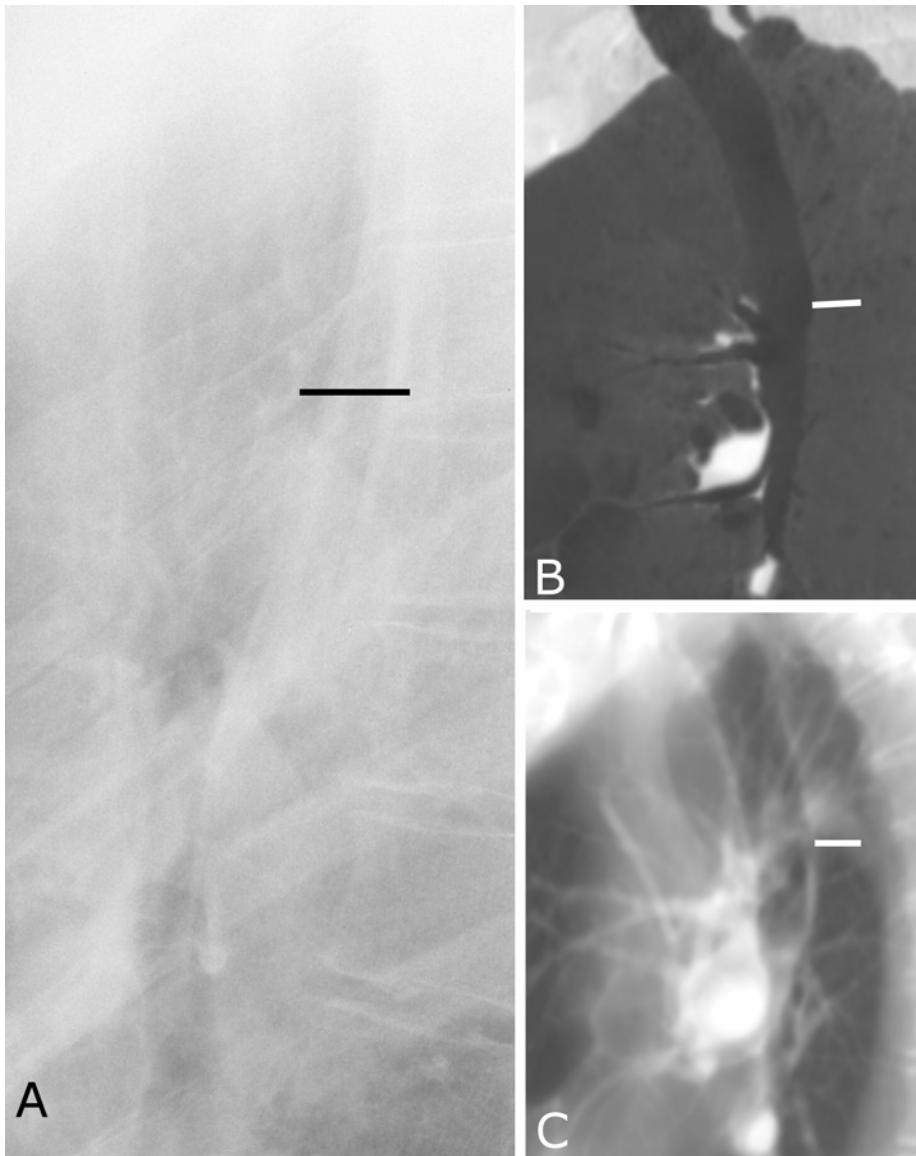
Central airways. A. Lateral radiograph of the chest showing the trachea. The carina can only be identified as an apparent decrease in diameter of the airway on the lateral radiograph. B. MinIP and C. Average intensity projection CT slab to show the anatomy in the same configuration as A.
